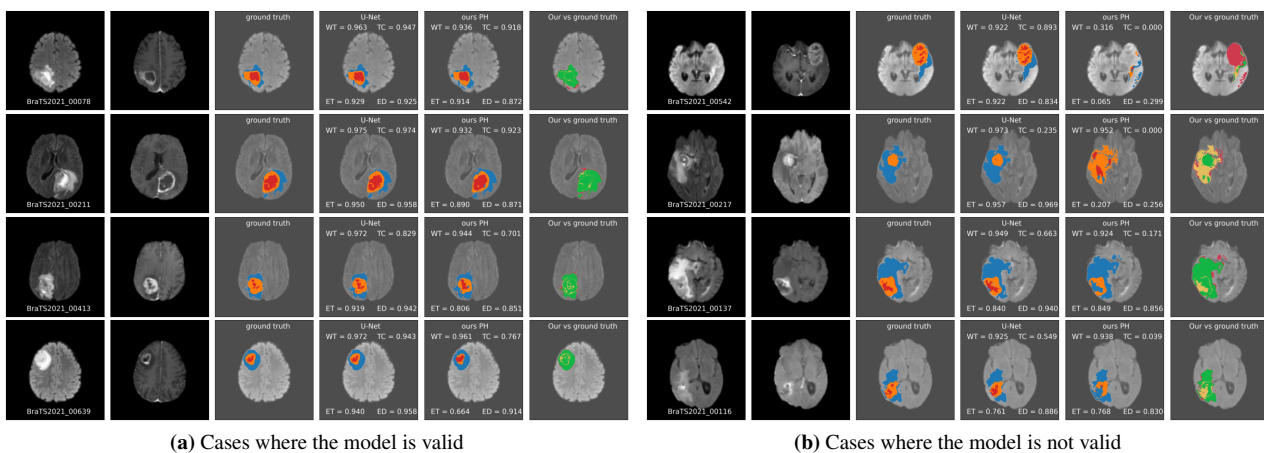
Results of our algorithm, in cases where the model is valid or not. On each row, from left to right: an image of modality FLAIR, of modality T1ce, the segmentation provided by the specialists and the segmentation we obtained with both U-Net and the PH method along with a comparison (green indicating well segmented, orange for mislabeled and red otherwise).
